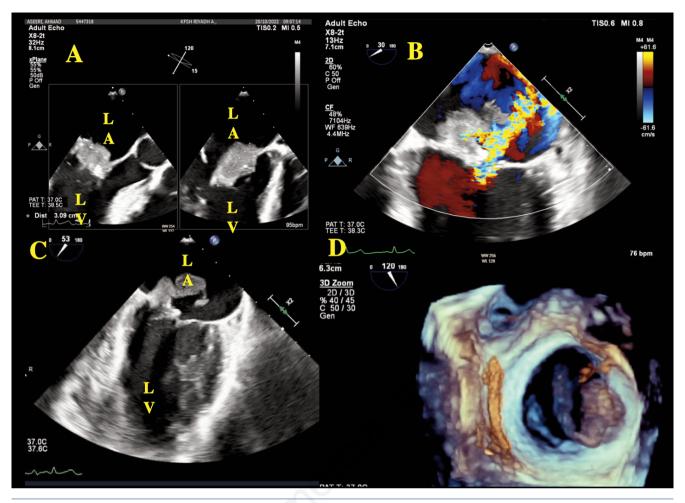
Transesophageal echocardiography. A) Mid-esophageal view at 120 degrees with X-plane orthogonal views in diastole showing the mass attached to the anterior mitral leaflet prolapsing into the left ventricle; B) mid-esophageal view, color Doppler across the mitral showing eccentrically directed jet and severe mitral regurgitation; C) bi-commissural view at mid-systole showing the mass attached to the A2 segment; D) 3D surgical view of the mitral valve showing the mass (attached to the atrial surface of anterior mitral leaflet). LV, left ventricle; LA, left atrium.
